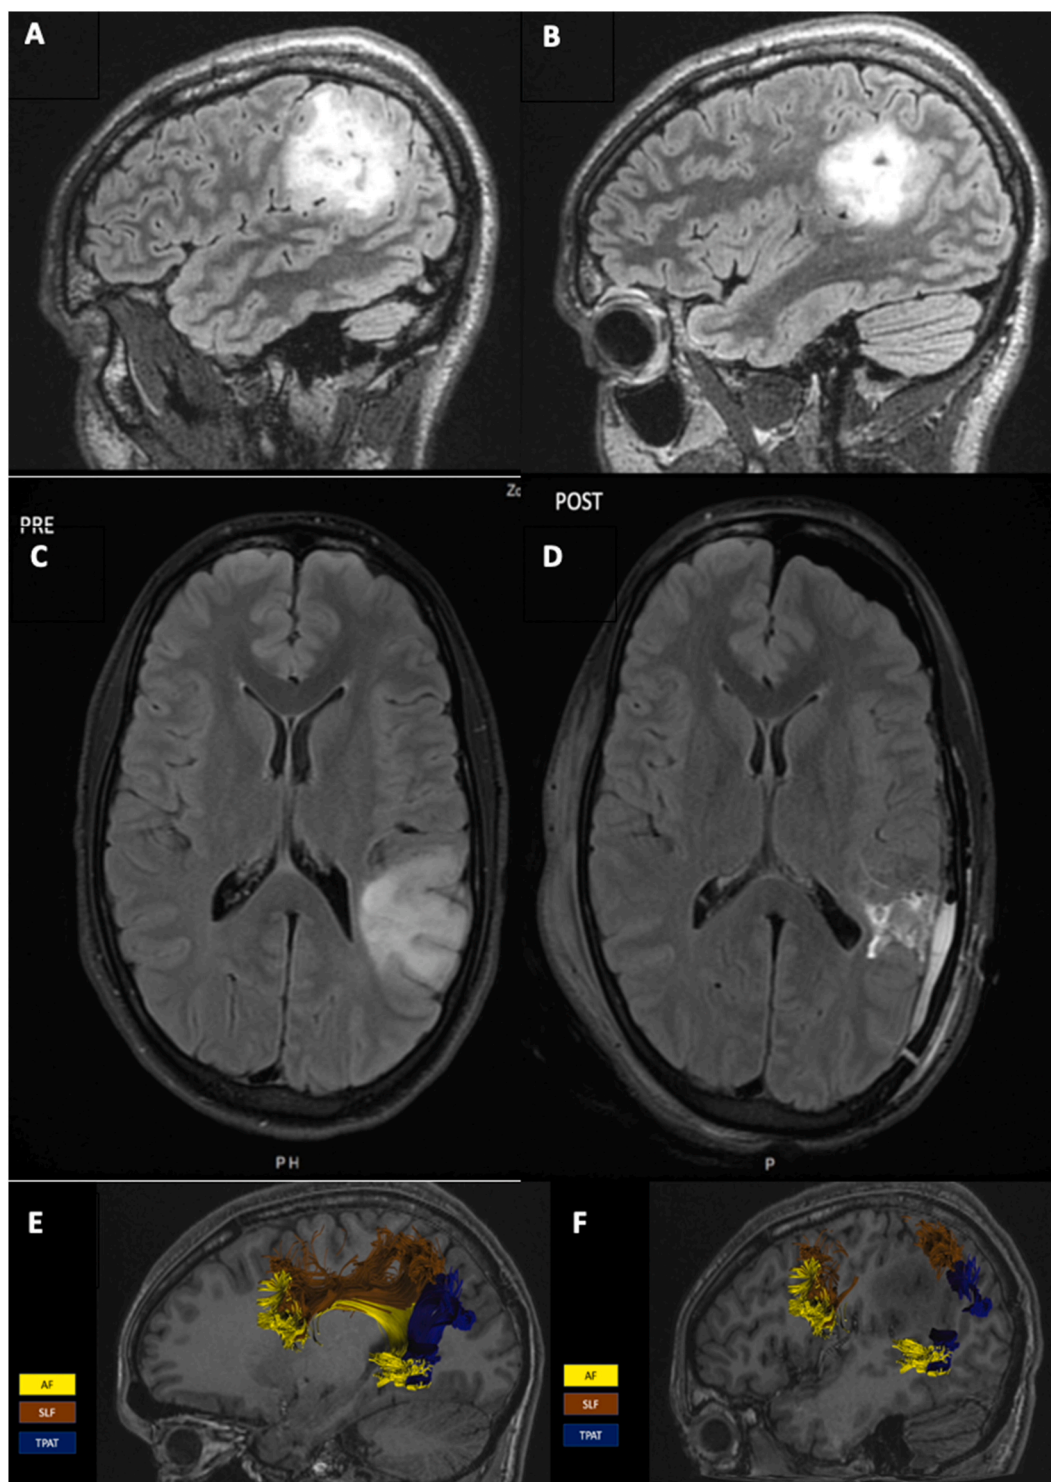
A & B Pre-operative Axial FLAIR MRI showing a left supramarginal low-grade glioma
